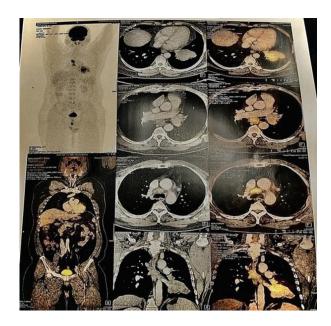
PET scan reveals increased FDG uptake in left lower lobe, increased FDG uptake in left hilar, subcarinal, and pre/paratracheal lymph nodes.
